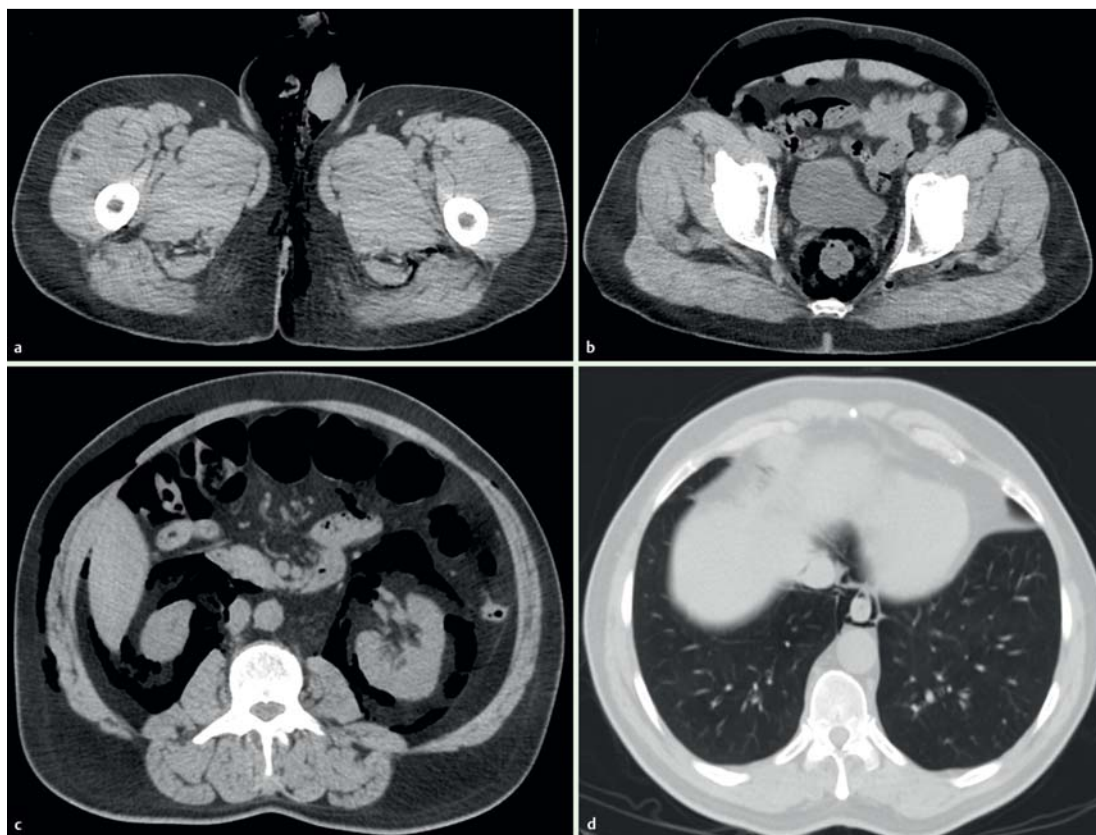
Computed tomography scans of the thorax and abdomen demonstrated: a pneumoscotum; b free air surrounding the rectal wall, c in the perinephric area on both sides, d and in the paraesophageal space.
